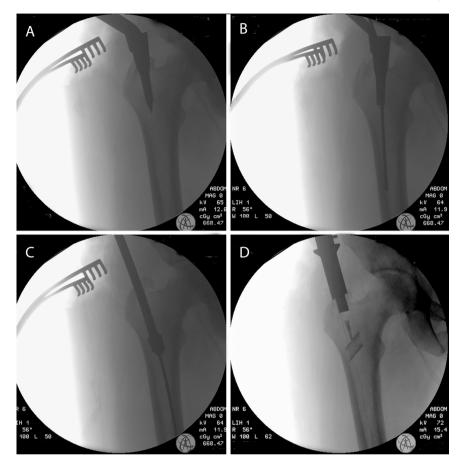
Intraoperative X-ray intensifier imaging showing the medullary canal opening (A), the K-wire inserted as guide inside after stylet removal (B), the canal reaming (C) and the nail being inserted inside the canal until the lag-screw marker is in right position (D).
